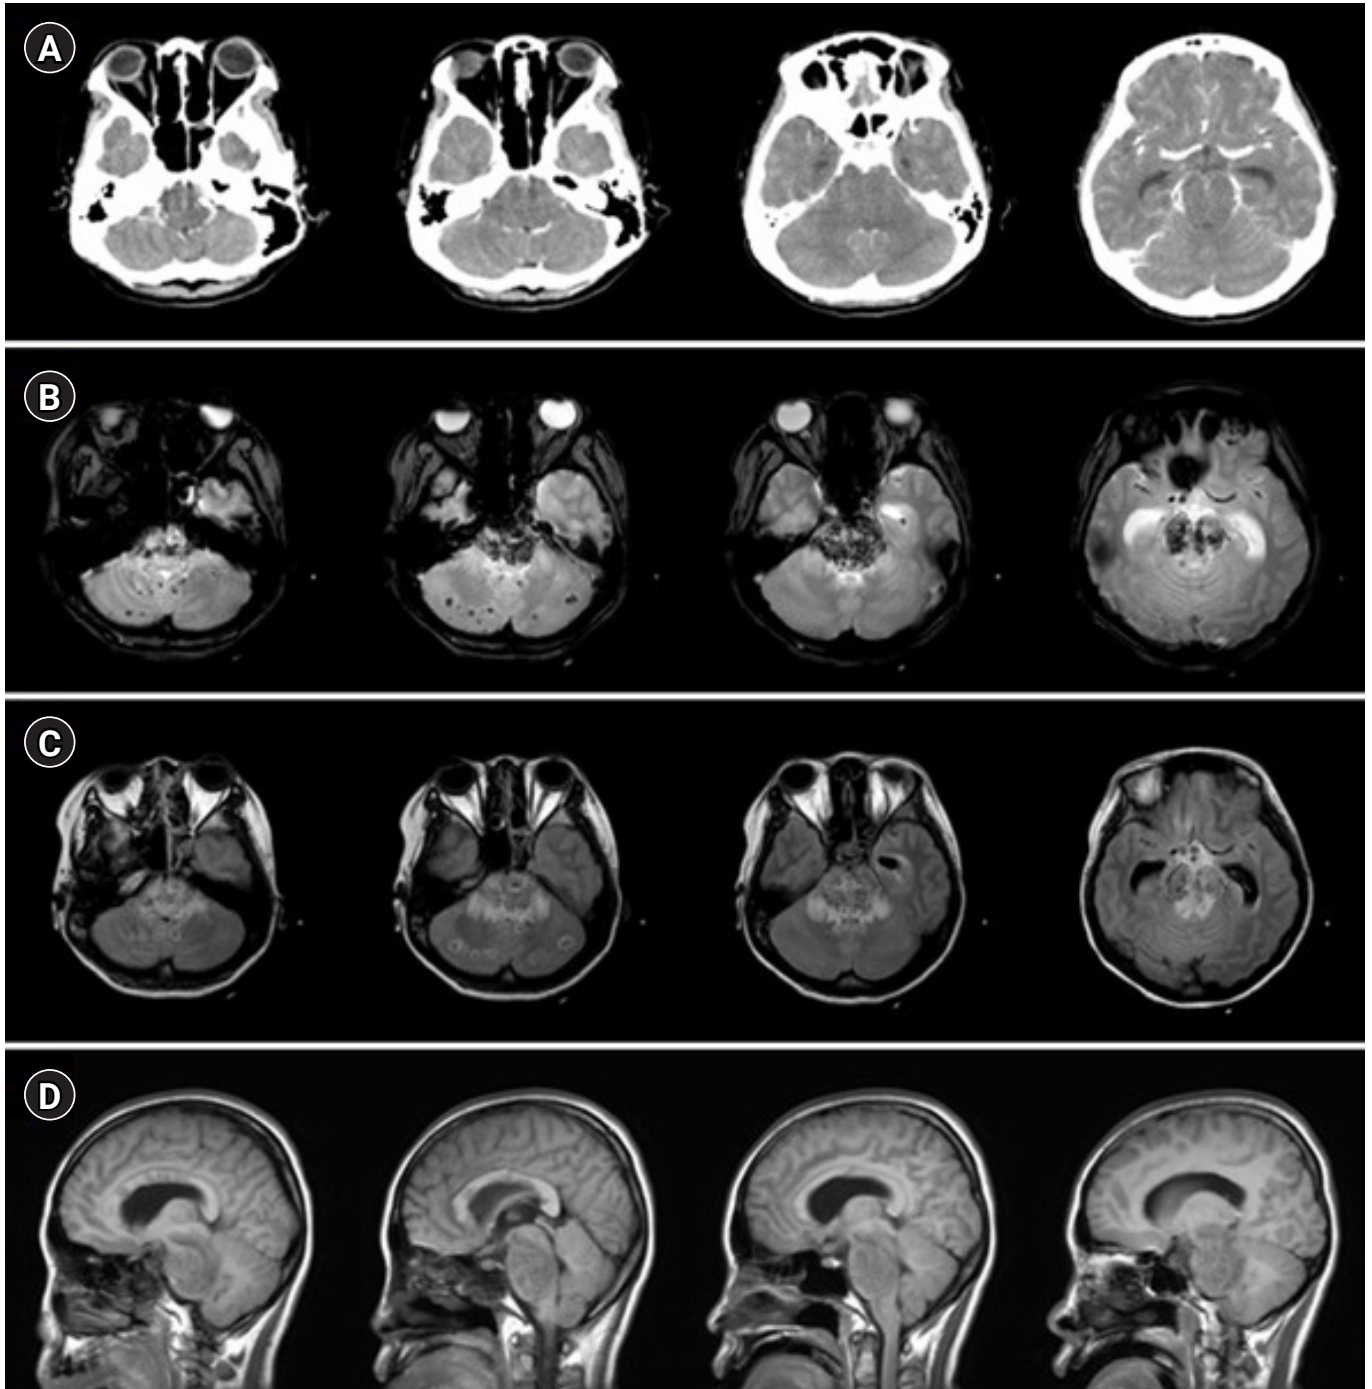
Computed tomography (CT) and magnetic resonance imaging (MRI) scans of the brain. (A) CT images demonstrate edematous brainstem without overt hemorrhage. (B, C) T2*-weighted gradient echo MRI images present extensive small foci of hypointensity, compatible with microbleeds, diffusely dispersed throughout the brainstem and cerebellum. T2-weighted fluid-attenuated inversion recovery images reveal edematous change around lesions. (D) Sagittal T2-weighted images indicate swollen brainstem, resulting in hydrocephalus.
